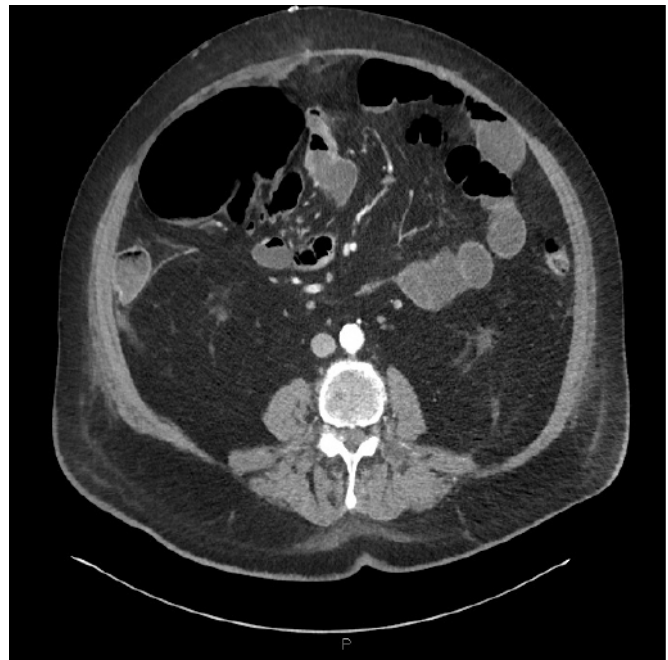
ED CT Showing Meckel's diverticulum. Published with Permission
